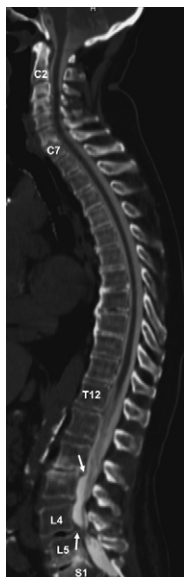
Degenerative spondylolisthesis: reconstructed panoramic sagittal CT myelogram—diffuse degenerative disk disease of the spine. Note mild retrolisthesis at L2-3 and anterolisthesis at L4-5 (*arrows*). Also note moderate degenerative central canal stenosis at L4-5.
